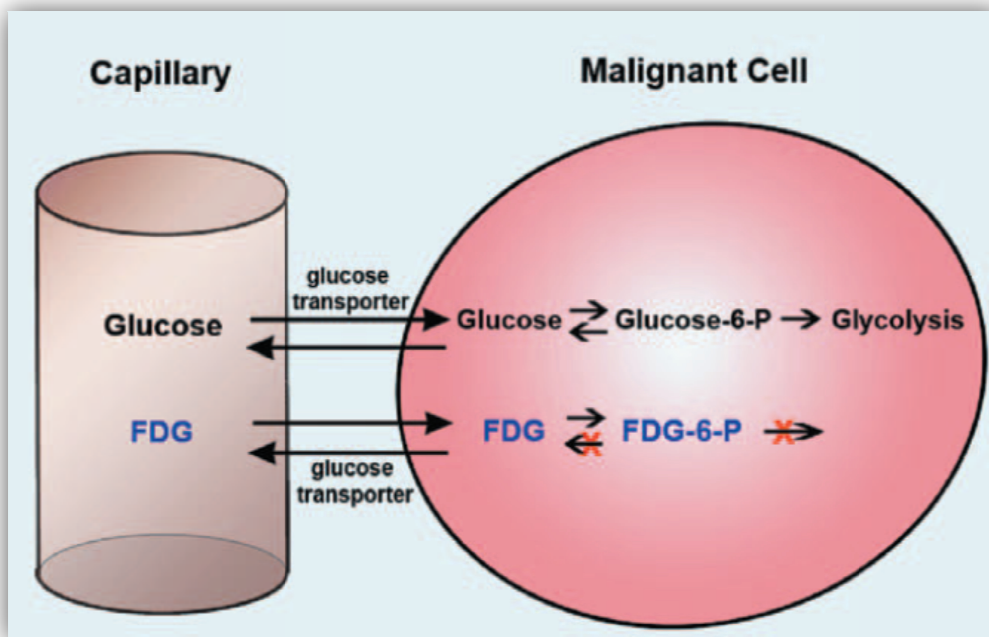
Comparison between the pathway of glucose and FDG in a malignant cell (1).
